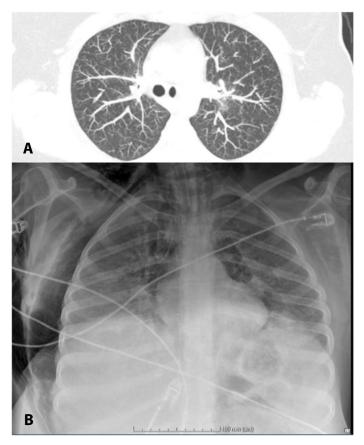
A) CT showing scan showing bilateral ground glass opacities and emphysematous changes. B) Pneumomediastinum, subcutaneous emphysema and bilateral pneumothorax.
